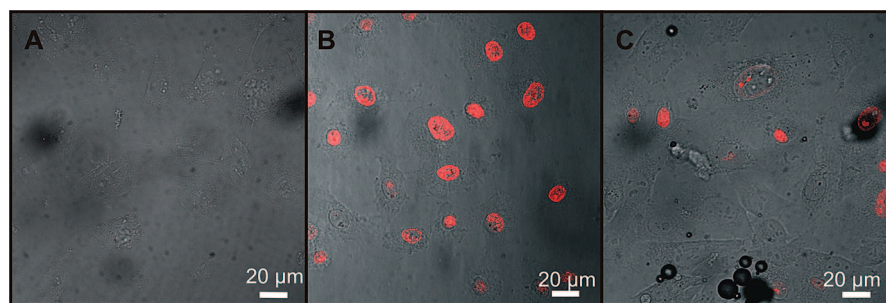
Cellular uptake of propidium iodide (PI) in BLM cells. (A) PI uptake during incubation of the cells with free PEGylated lipoplexes. (B) PI uptake in cells simultaneously exposed to PI, free PEGylated lipoplexes, microbubbles and ultrasound. (C) Confocal image of cells that were first treated with free PEGylated lipoplexes, microbubbles and ultrasound and subsequently, after 15 min, exposed to PI.
